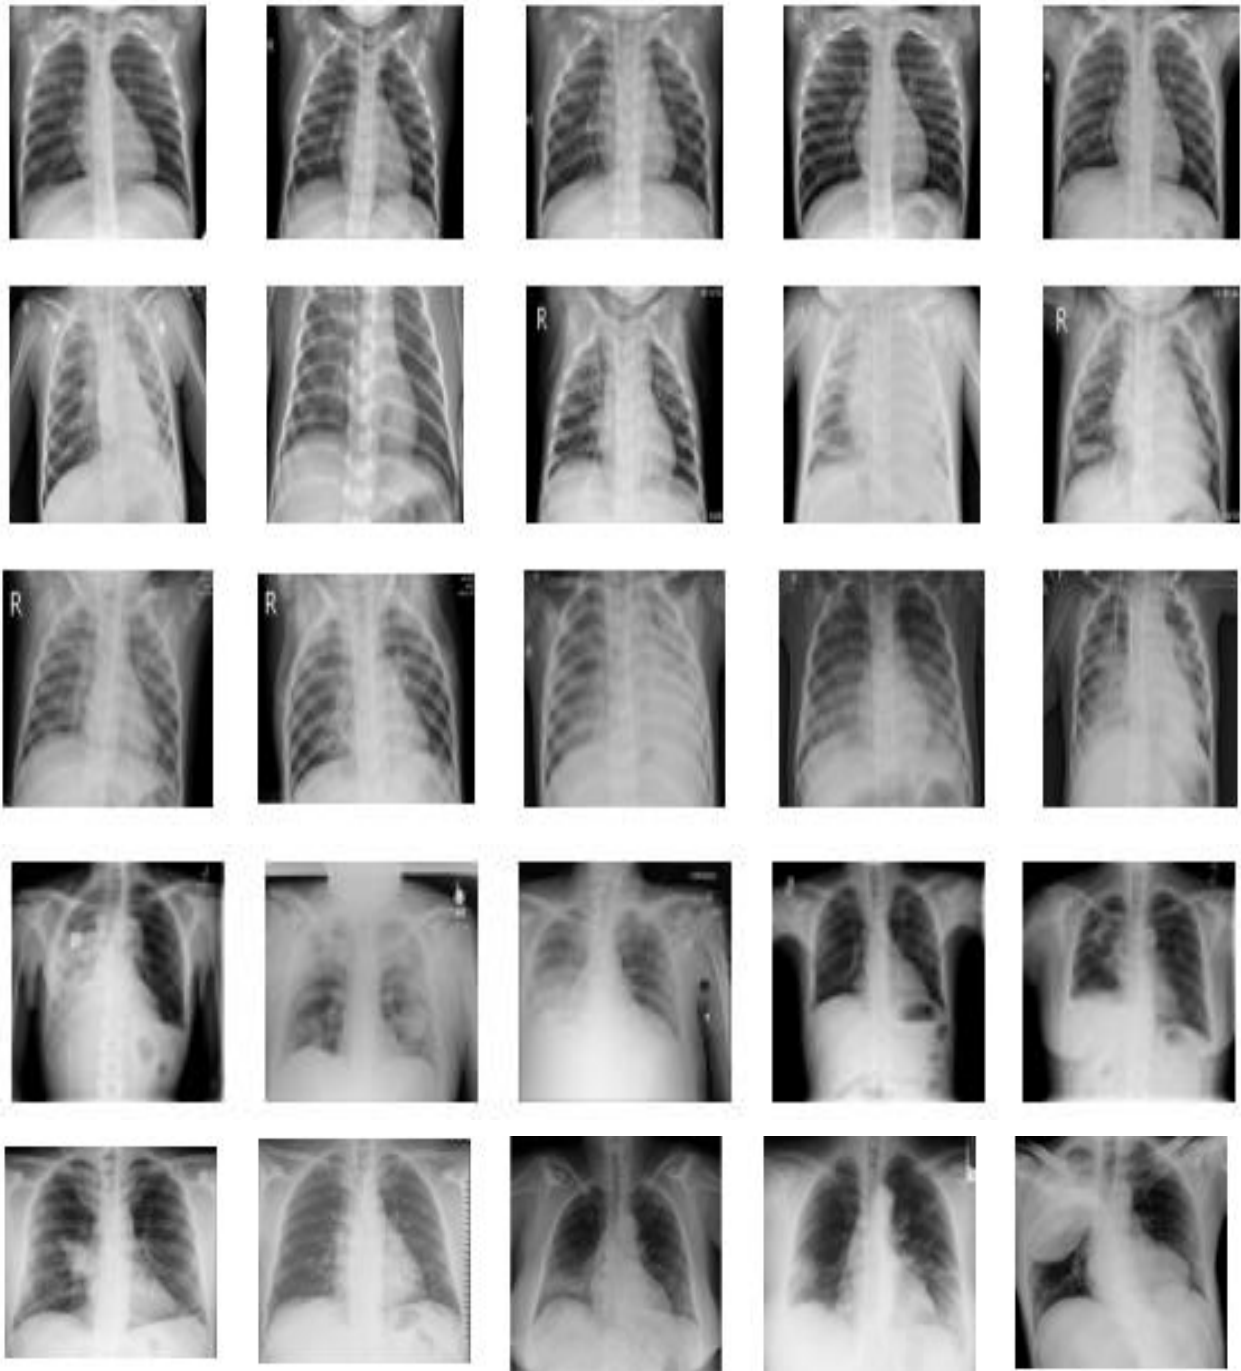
Sample datasets for Chest X-ray image
